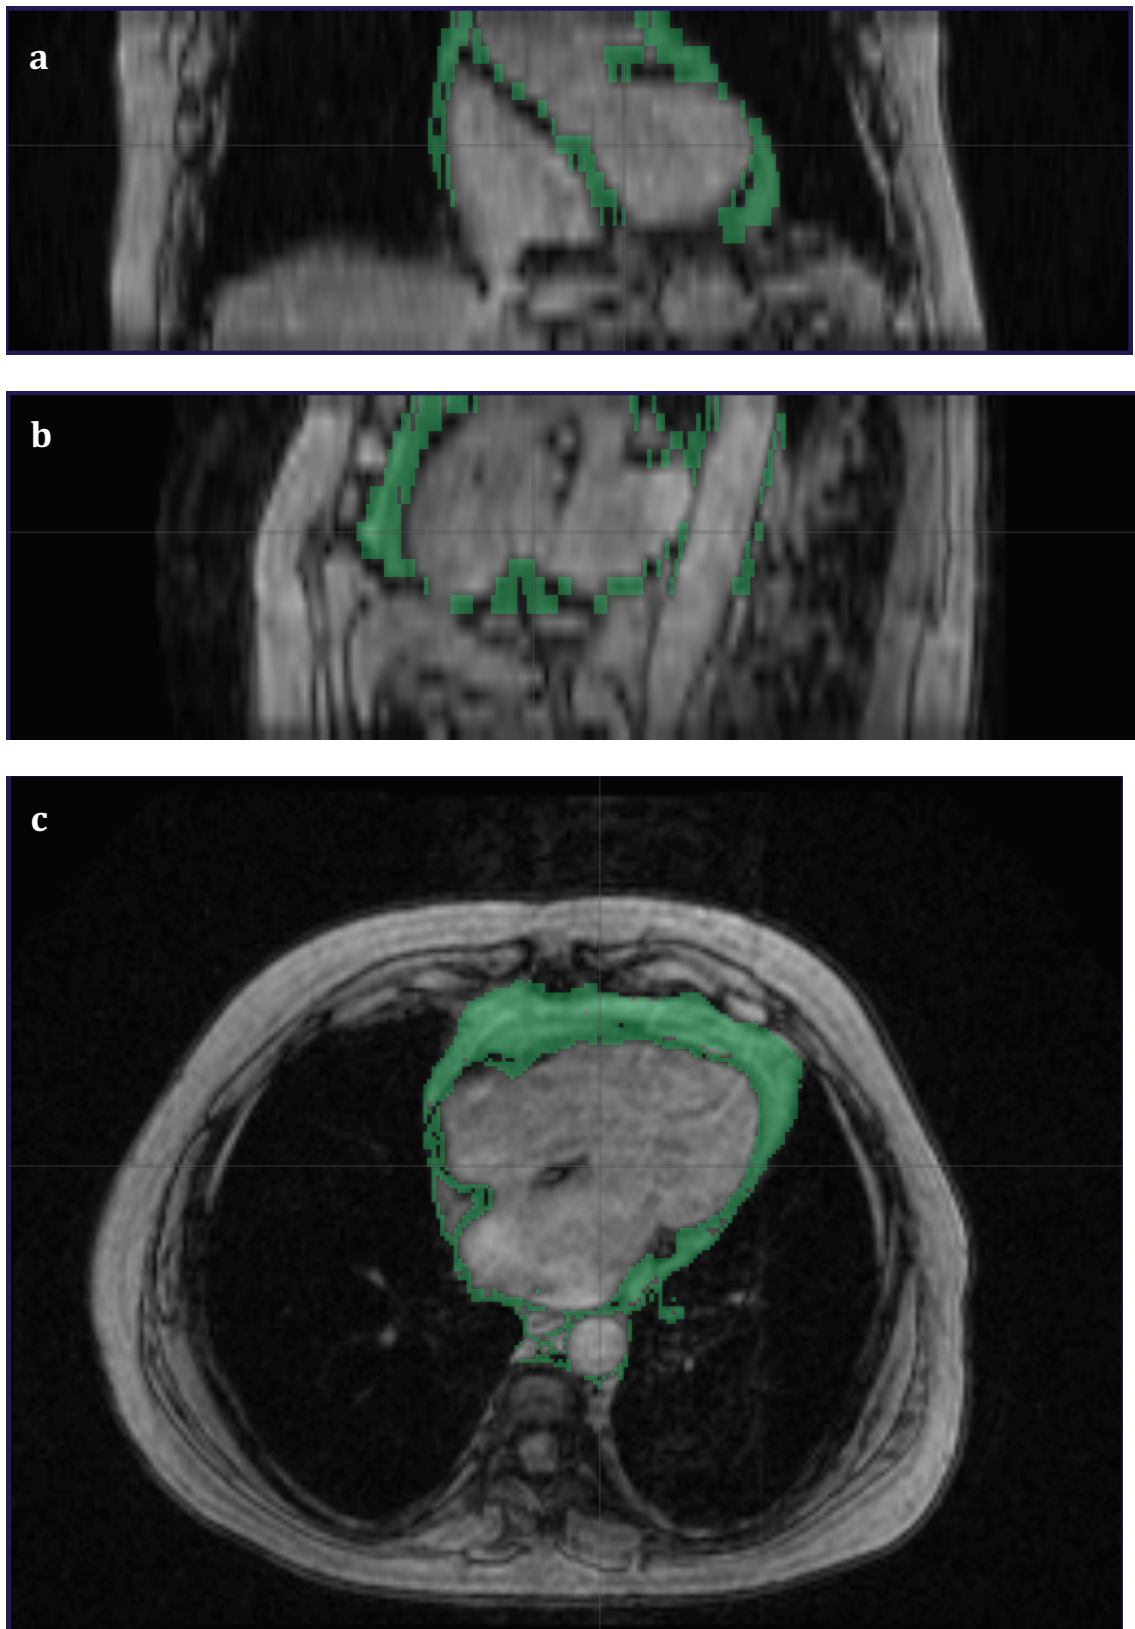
Representative example of epicardial and intrathoracic fat volume quantification by MRI; epicardial fat is highlighted in blue, intrathoracic fat – in green;; a: axial, b: coronal, c: sagittal view
